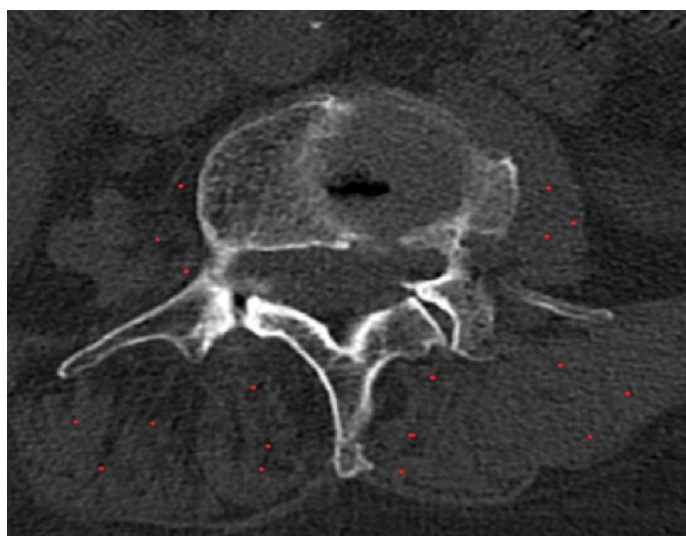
Density measurement with Hounsfield units from computed tomography using 3 random points from each muscle.
